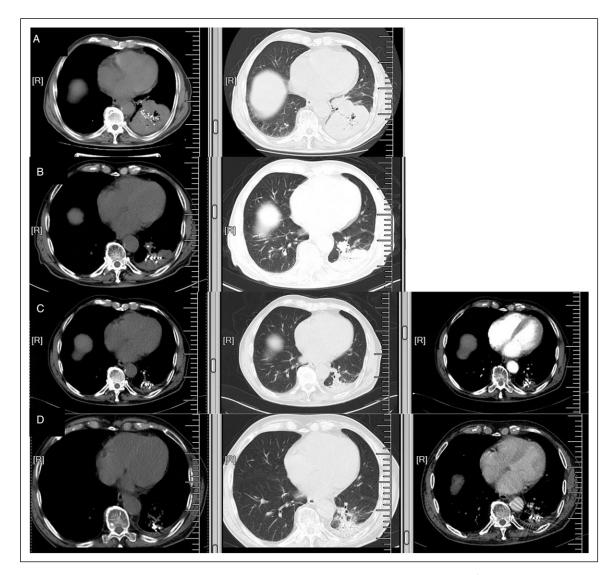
The lesion on chest CT during chemotherapy. (A) The maximal cross-section of lesion was 87 mm*63 mm and the maximal mediastinal lymph node was 43 mm on chest CT on August 22th, 2019. (B) The maximal cross-section of lesion was 46 mm*30 mm and the maximal mediastinal lymph node was 30 mm on November 11th, 2019. (C) The maximal cross-section of lesion was 40 mm*25 mm and the maximal mediastinal lymph node was 30 mm on March 2nd, 2020. (D) The maximal cross-section of lesion was 40 mm*25 mm and the maximal mediastinal lymph node was 30 mm on March 2nd, 2020. (D) The maximal cross-section of lesion was 40 mm*25 mm and the maximal mediastinal lymph node was 30 mm on June 4th, 2020.
